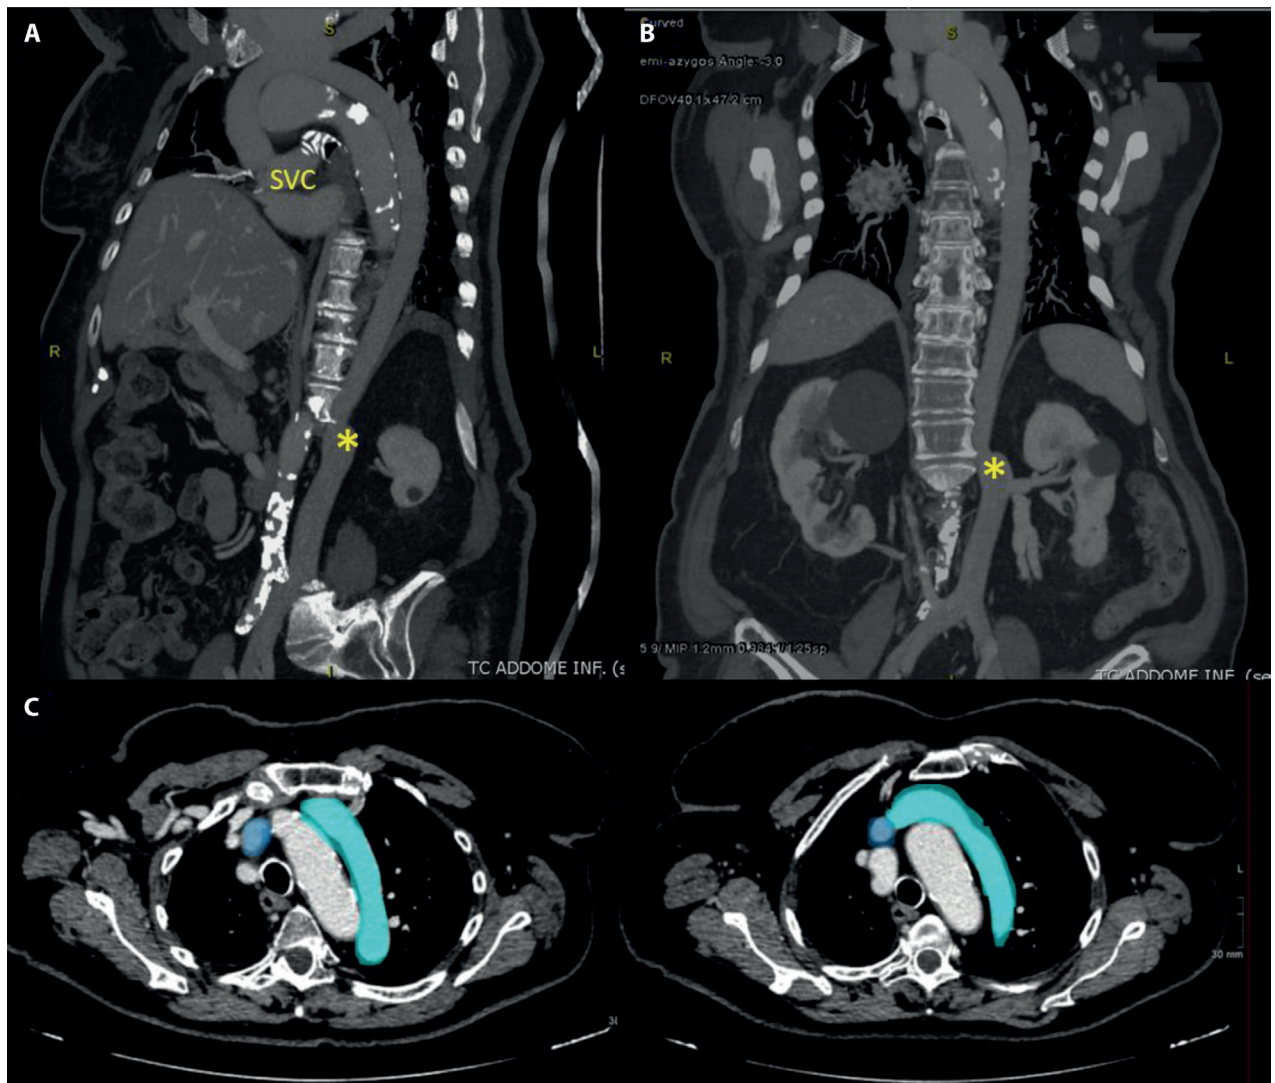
Portal phase of a Whole Body-CT scan with MIP application. a) sagittal plane showed the accessory hemiazygos arch from the Superior Vena Cava (SVC) and the continuation of the hemiazygos vein. b) coronal plane showed the accessory hemiazygos arch, the entire course of the hemiazygos vein flowing at the left side of the vertebral column, its origin from the common iliac veins. At the L1-L2 level, the hemiazygos overpassed the diaphragmatic pillar (*) c) axial plane images showed the entire arch on the left side of the aortae and the accessory hemiazygos arch joining the Superior Vena Cava. Blue: Superior Vena Cava; Light blue: accessory hemiazygos arch.
